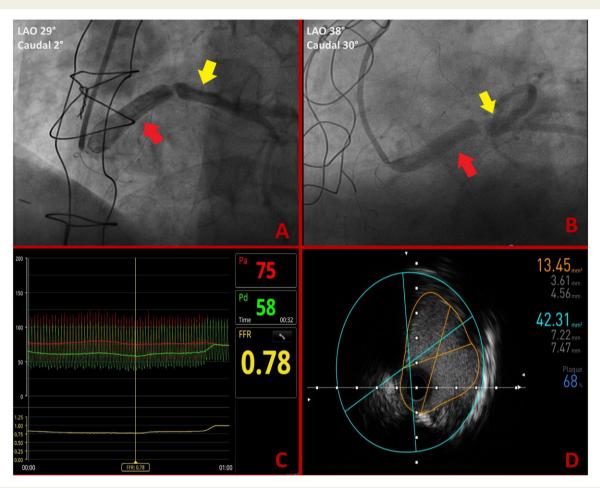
Cath-lab assessment of the Cabrol conduit stenosis. The red arrow shows the prosthetic conduit; the yellow arrow shows the native left main stem. (A, B) Invasive coronary angiography showing a hazy image between the Cabrol conduit and the left main. (C) Functional assessment with fractional flow reserve. (D) Intravascular ultrasound scan, at the site of the conduit narrowing; quality of the intravascular imaging is suboptimal, principally due to the considerable graft diameter.
